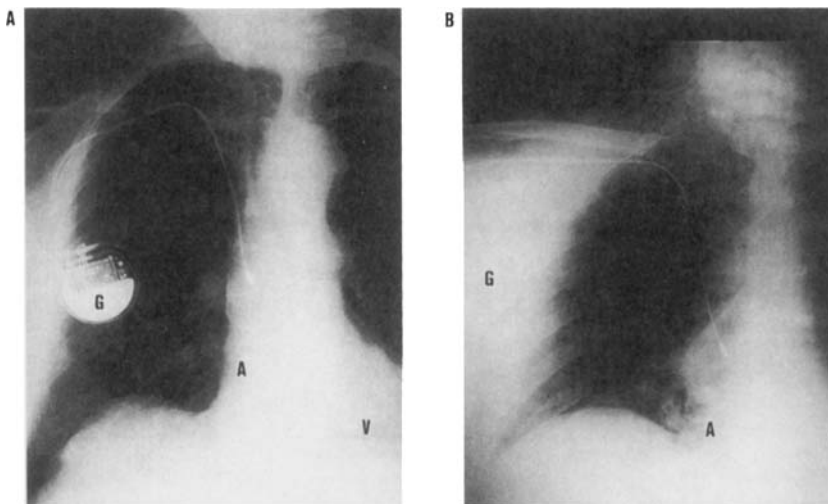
(A) Preoperative and (B) immediate postoperative chest radiographs showing the position of pulse generator (G) and of atrial (A) and ventricular (V) electrodes. (B) Reveals displacement of the pulse generator toward the shoulder by edema and shows traction on both the atrial and the ventricular leads.
